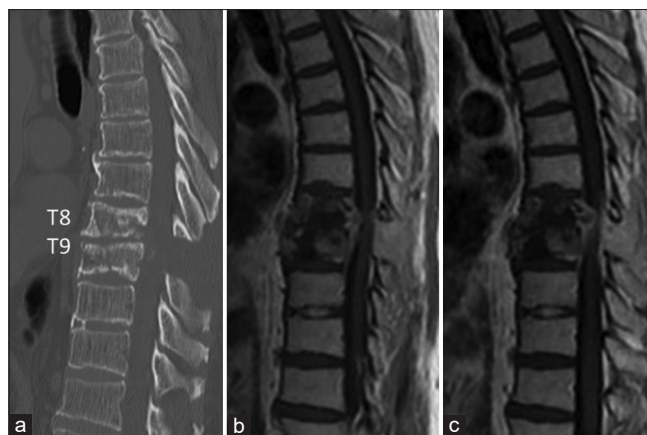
After first surgery, postoperative follow-up images. (a) Follow-up computed tomography scan 3 months later showing the same size of bony destruction with no change in thoracic kyphosis. (b) Three-month follow-up sagittal T1-weighted magnetic resonance imaging with contrast, showing the same size of paravertebral abscess. (c) Six months later, sagittal T1-weighted magnetic resonance imaging with contrast shows increased size of the paravertebral abscess with dural compression and increased kyphosis at the same level
